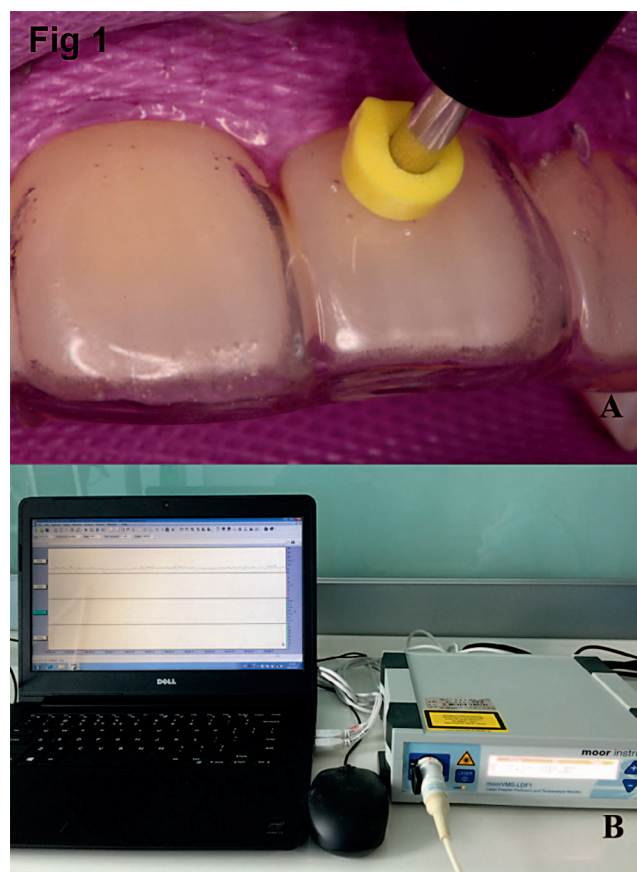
Photographs showing the recording of laser Doppler. (A): View of the placement of rubber dam, acrylic guard, and application of the LDF tester. (B): Setup for the recording of the laser Doppler.
